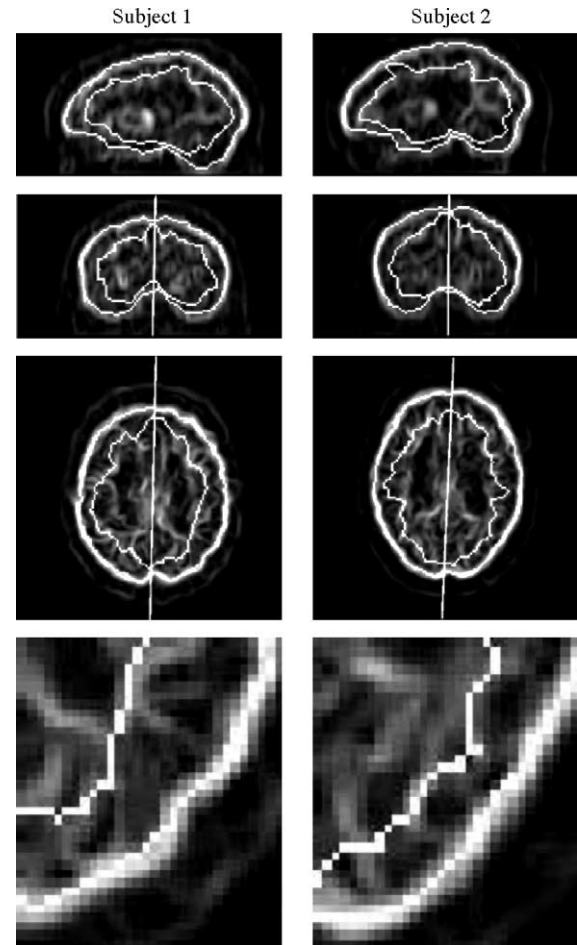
Examples of the automatically delineated brain surfaces, mid-sagittal planes and white matter surfaces from the FDG-PET brain images of overlaid on the energy image. Based on the visual quality of the white matter surfaces, subject 1 is a typical result and subject 2 is the worst result, cf. the text. From top, the sagittal, coronal and transaxial cross-section views. The mid-sagittal plane is marked only on the coronal and the transaxial cross-sections. Bottom, magnifications (500%) of the lower right corner of the transaxial image cross-section are shown.
